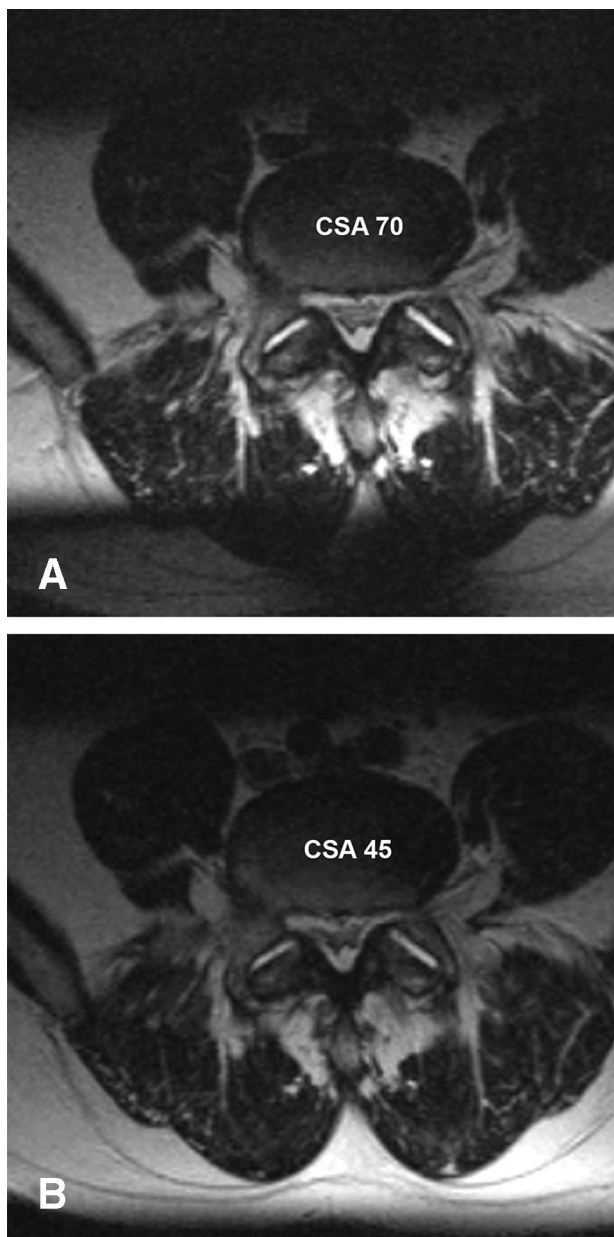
Patient MR18 (Tables 1 and 2). A 55-year-old man with low back pain and severe neurogenic claudication in walking and standing. Axial loaded MRI disclosed a spinal stenosis in the L3–L5 levels. The L4–L5 level is demonstrated in PRP (A) and ACE (B). Decompression was performed in both levels. One year after surgery, he was much improved regarding his back and leg pains, and he could walk in a normal pace for more than 1 km compared with less than 500 m before surgery.
